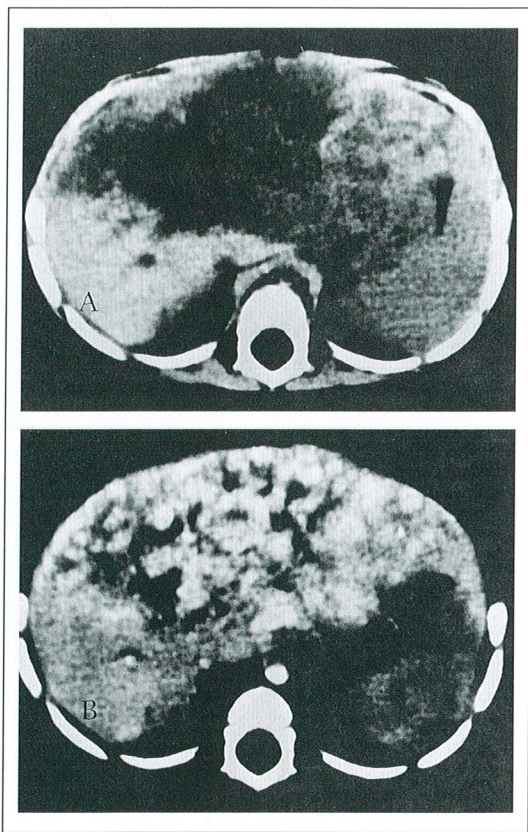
(A) CT scan shows a diffuse infiltrative hypodense lesion in the complete left and partial right lobe of the liver. In the lesion there are more hypodense local areas that correspond to hypoechoic areas in US images. (B) Contrast enhanced CT scan shows that lesion enhances generally. More hypodense areas do not show enhancement.
